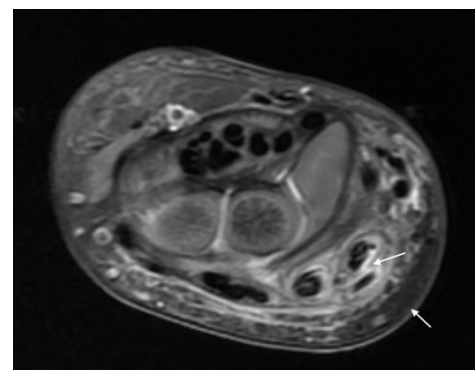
MRI axial proton-density-weighted fat-suppressed image shows extensive fluid around the II and III extensor wrist compartment tendons with tendon sheath thickening (arrow), related to acute tenosynovitis. Diffuse edema is seen in the adjacent soft tissue of the dorsal wrist (arrow).
